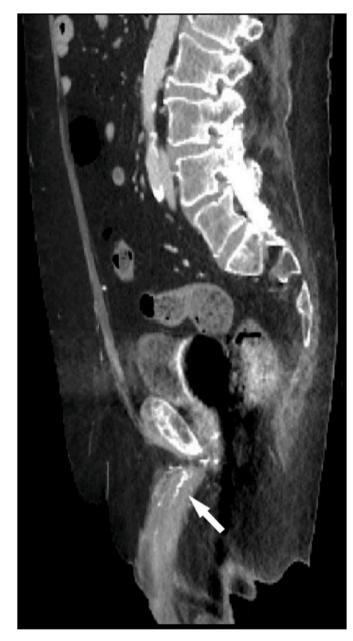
Calcification at CT examination. It shows prostatic and penile abscess, the dorsal penile one has bubble in it. We can also see small penile arteries with calcifications (arrow).
